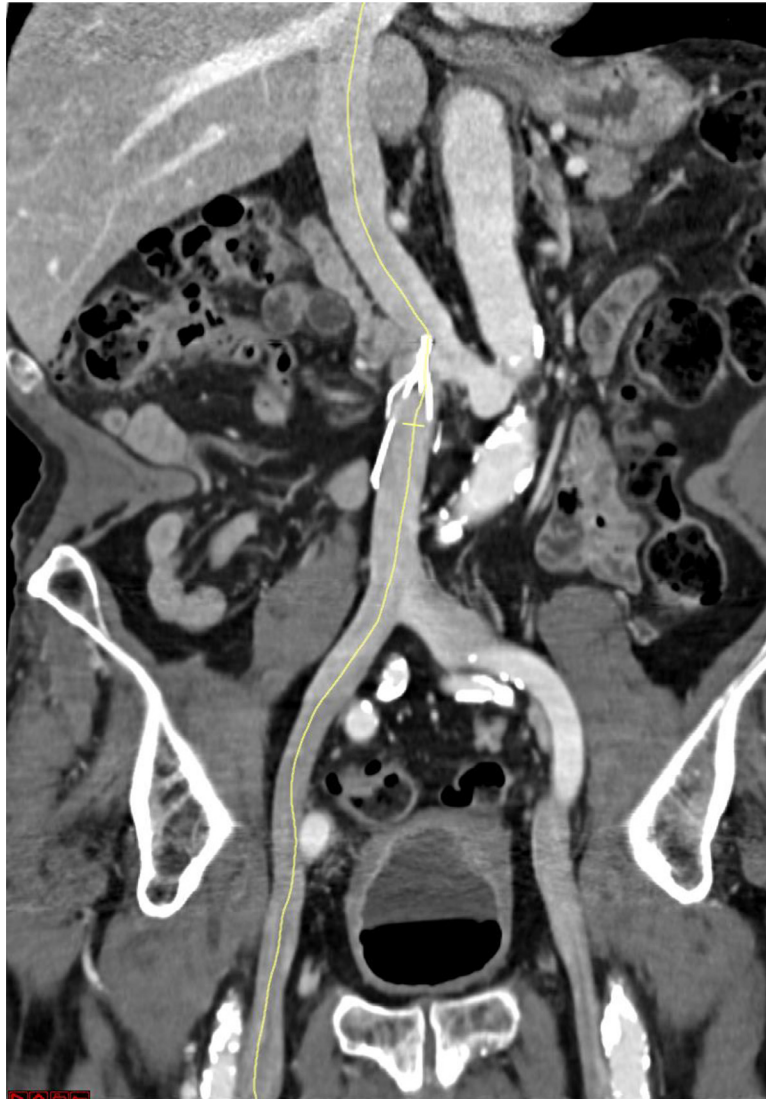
Contrast-enhanced CT of the abdomen (coronal view). Complete recanalization of thrombosis.
